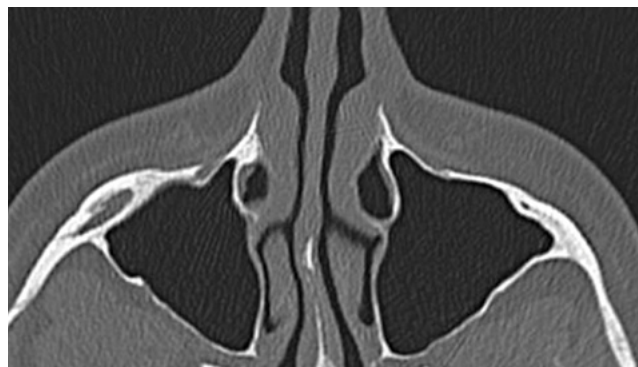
CT image of June 2016 (axial view) showing a healthy and well-developed right maxillary sinus.
